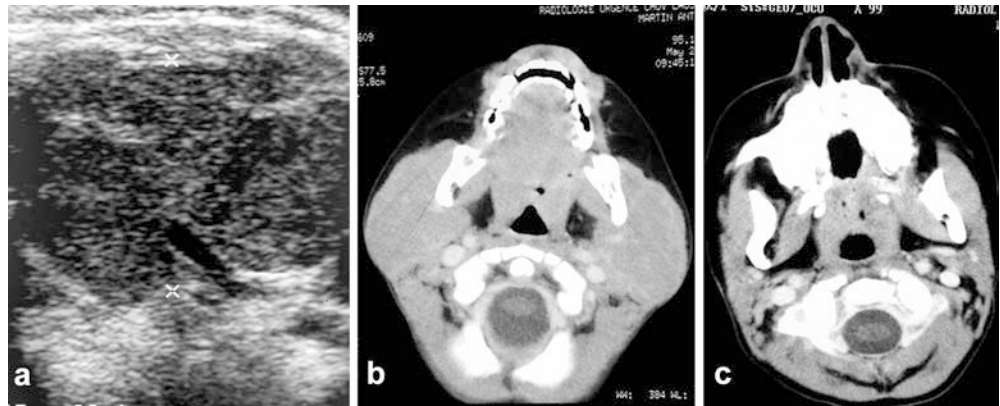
a Cervical US of a 3-year-old boy demonstrates bilateral symmetrical enlargement of the parotid glands, confirmed by CT (b) and owing to diffuse histiocytic infiltration. c After chemotherapy size returned to normal 20 months later
